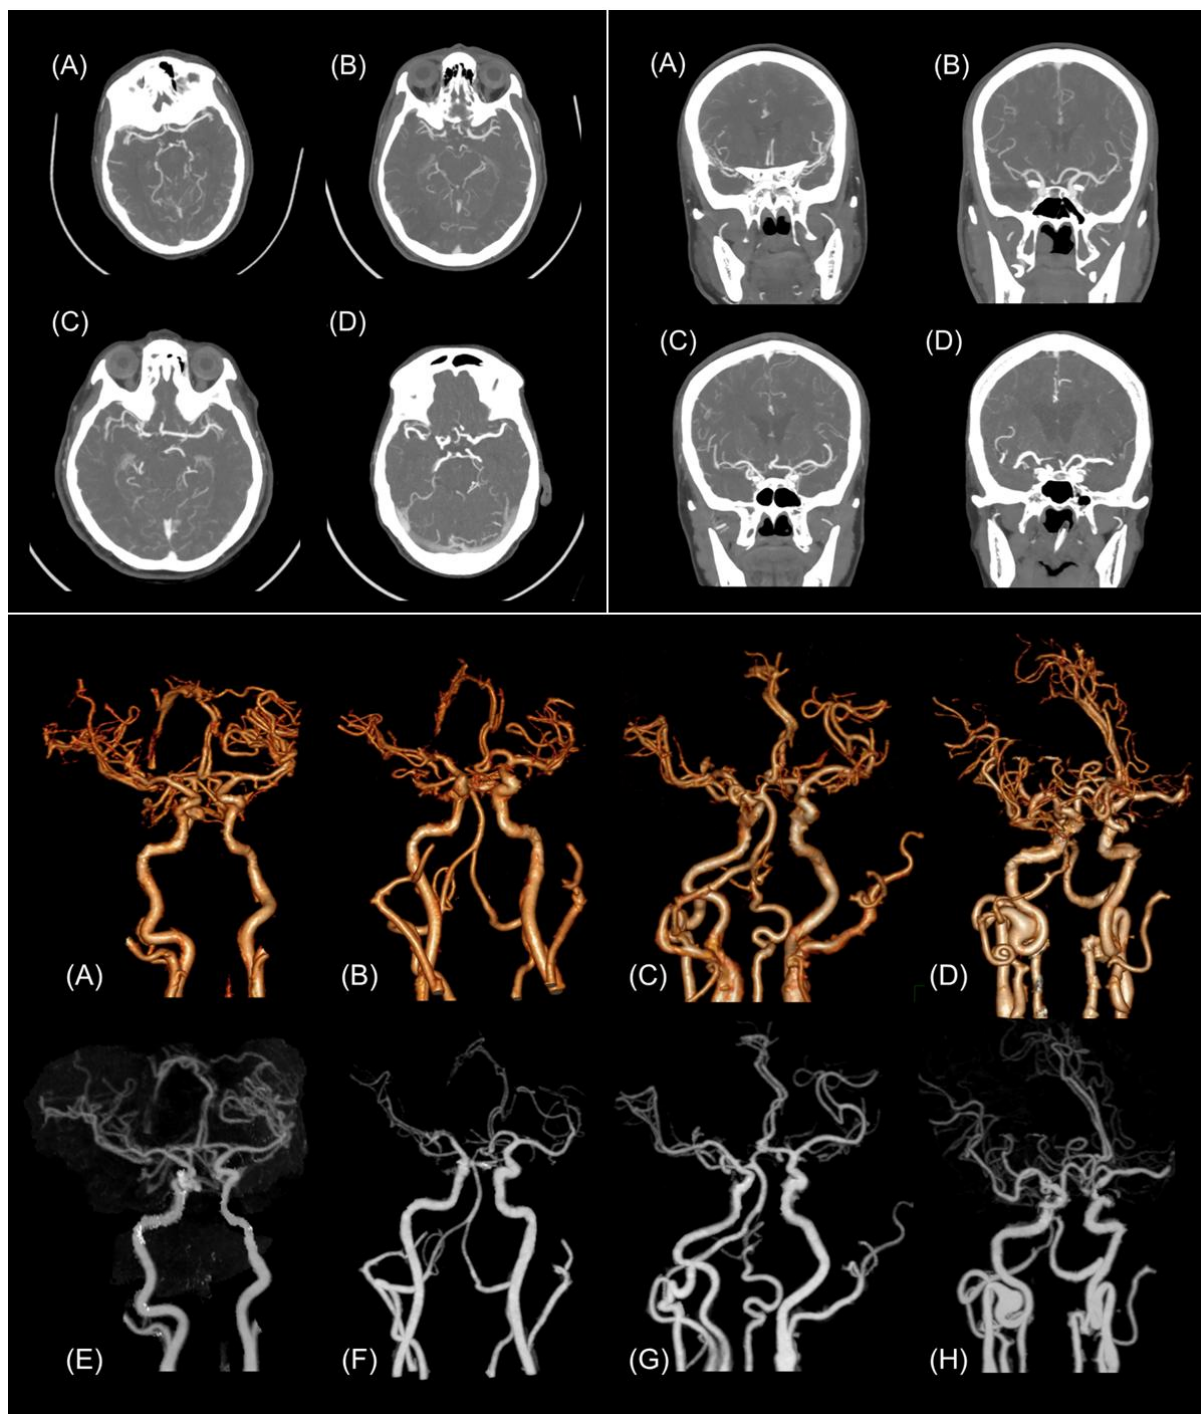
An axial, coronal, VR and MIP images of a cerebral vessels. CT images of a (A, E) 36 years old female patients scanned with protocol, (B, F) 33 years old male patients scanned with protocol B, (C, G) 50 years old female patient scanned with protocol C, and (D, H) 73 years old female patient scanned with protocol D.
